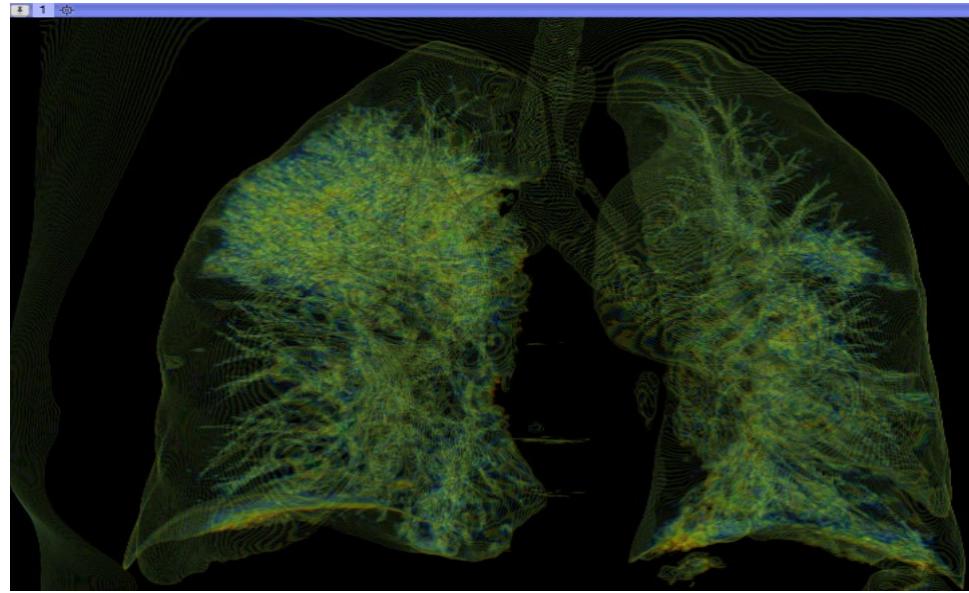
COVID Patient 19 Lung CT Scan: 3D volume rendering with cropped ROI using 3D Slicer
